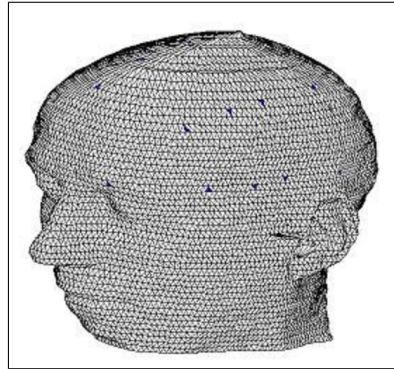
Realistic scalp model developed from T1 weighted human brain MRI data containing 16188 triangles and 7800 vertices.
